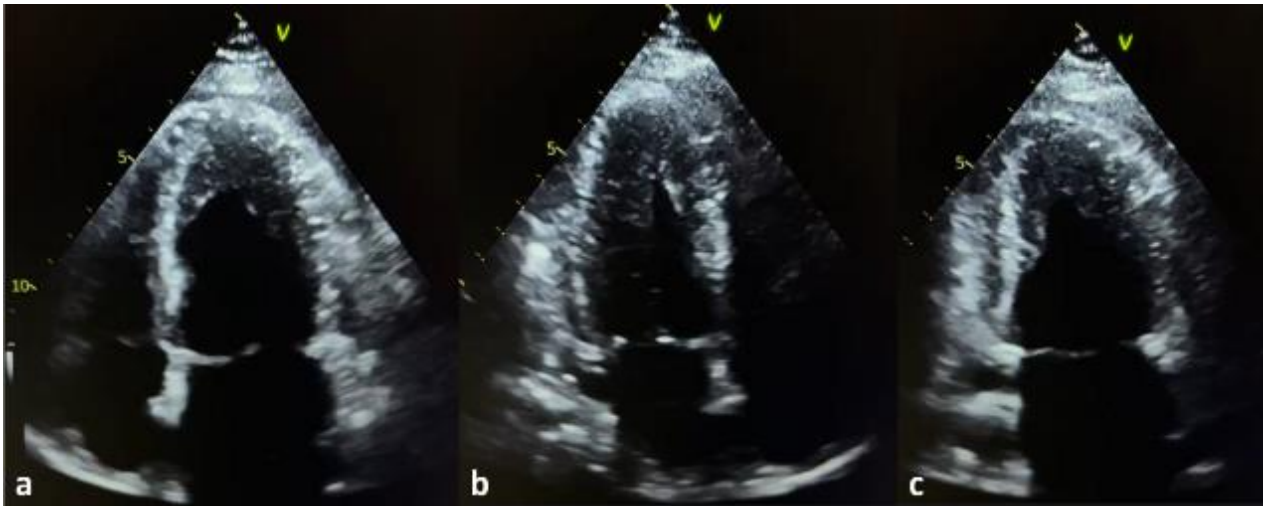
Transthoracic echocardiography in apical views demonstrating marked myocardial hypertrophy confined to the left ventricular apex with the characteristic "spade-like" cavity configuration. (a) Apical four-chamber view; (b) Apical three-chamber view; (c) Apical two-chamber view
